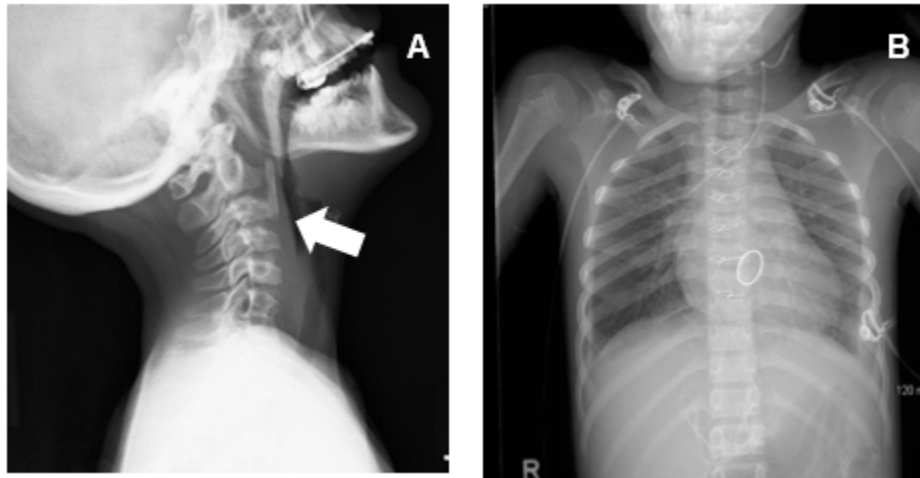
Radiographs of a female with Myhre syndrome at age 14 years
